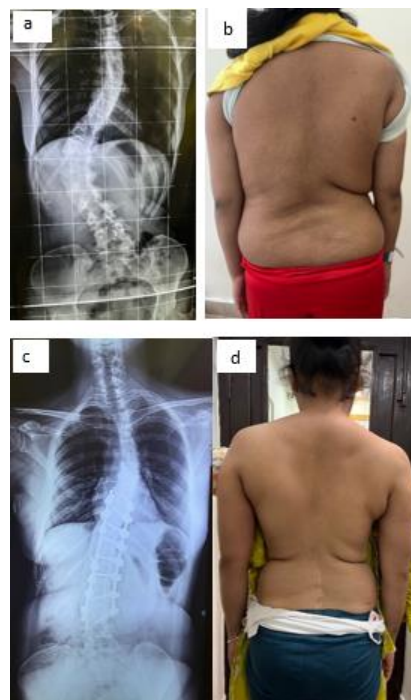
a: Preoperative X-ray AP view showing the Left Thoracolumbar Scoliosis (Cobb 70°); b: Preoperative Clinical photo showing the curvature; c: 2 year post op X-ray AP view showing corrected Thoracolumbar spinal curvature; d: 2 year post op clinical photo showing well corrected spine.
